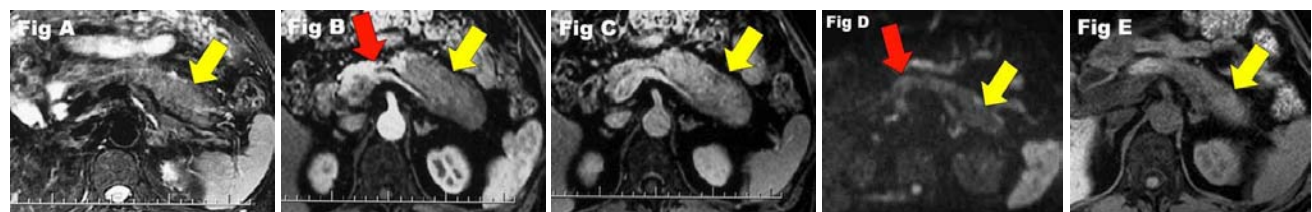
Focal autoimmune pancreatitis of the pancreatic tail in a 67-year-old man. The lesion (yellow arrow) also showed mildly hyperintense on fat saturated T2WI (Fig A), decreased persusion on arterial phase image (Fig B), delayed enhancement on equilibrium phase image (Fig C).However, compared with the normal pancreatic parenchyma, the lesion (yellow arrow) showed mildly hypointense on DWI (Fig D), and the ADC value of the lesion was $1.84 \times 10^{-3} \text{mm}^2/\text{s}$. Imaging abnormalities resolved on follow-up fat suppressed T1WI (Fig E) after 4 months of steroid therapy.
